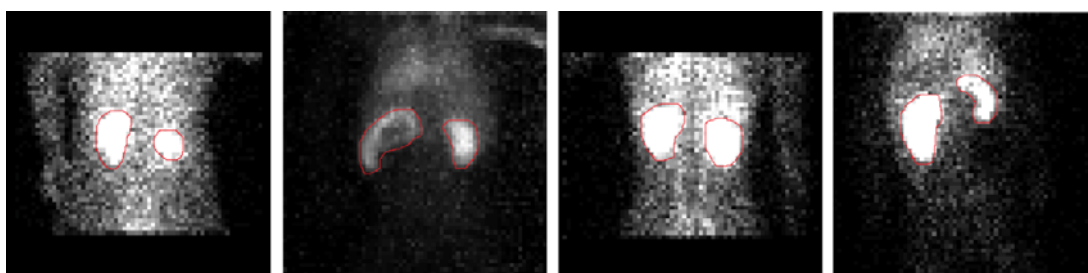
Manual segmentation by expert of kidneys on renal scintigraphy
